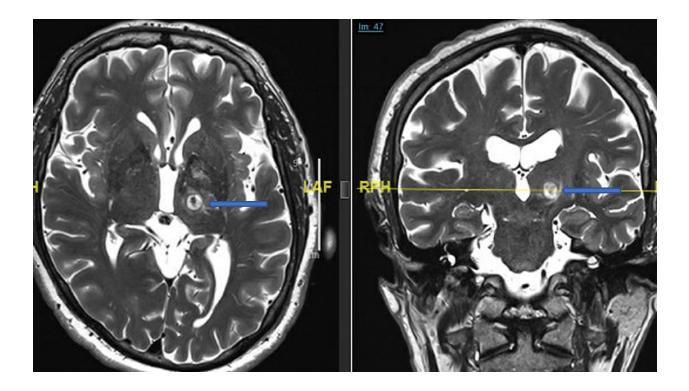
MRI images of the brain following Focused US Thalamotomy for treatment of ET shows the lesion (blue arrow) involving the left VIM. Left sided thalamic lesions are used to treat right sided tremor while right sided lesions are used to treat left sided tremors (Lak AM, et al. MRI Guided Focused Ultrasound Thalamotomy. A Single Center Experience with 160 Procedures. Front. Neurol. Volume 13. February 18, 2022).
